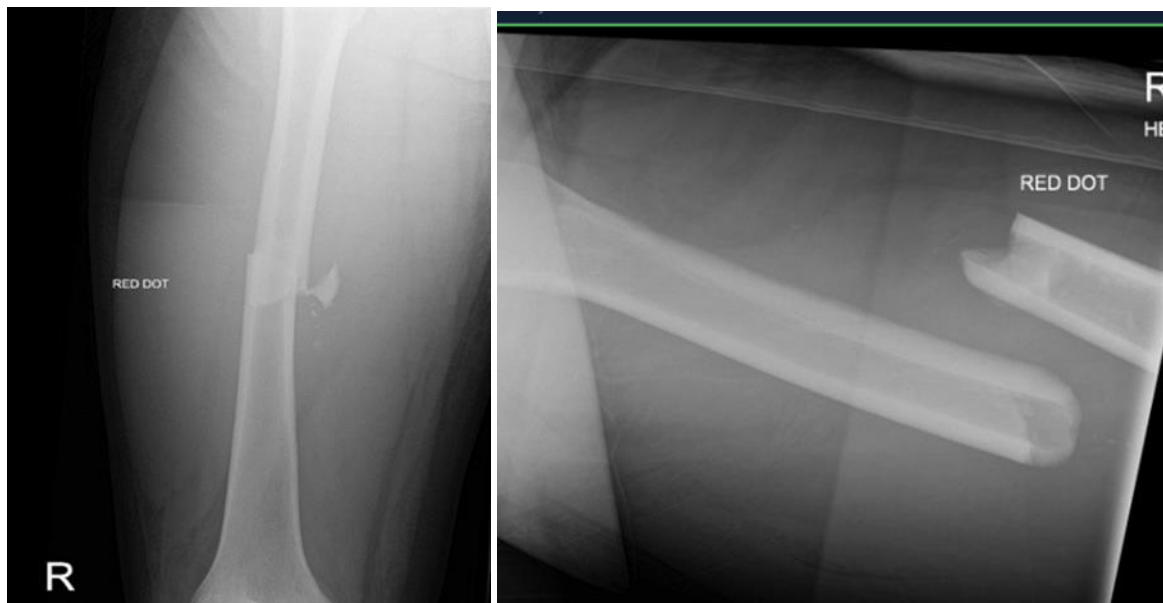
X-rays of Femur taken during second visit
